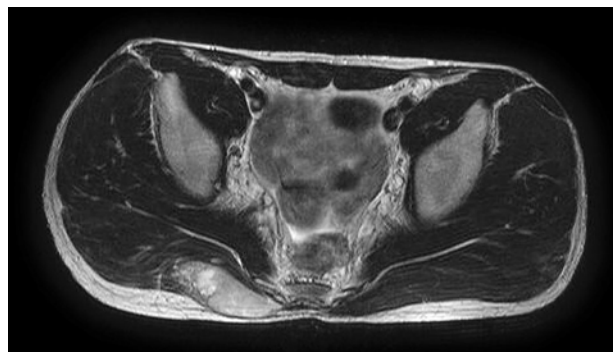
Magnetic resonance imaging. Axial T2-weighted image shows heterogeneously high signal intensity in the right buttock mass.
